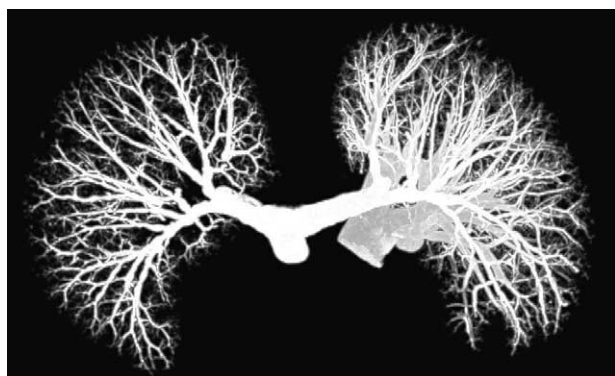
Max-intensity projection of a 6 cm horizontal slab of the HRCT data displayed with inverted grey scale.
